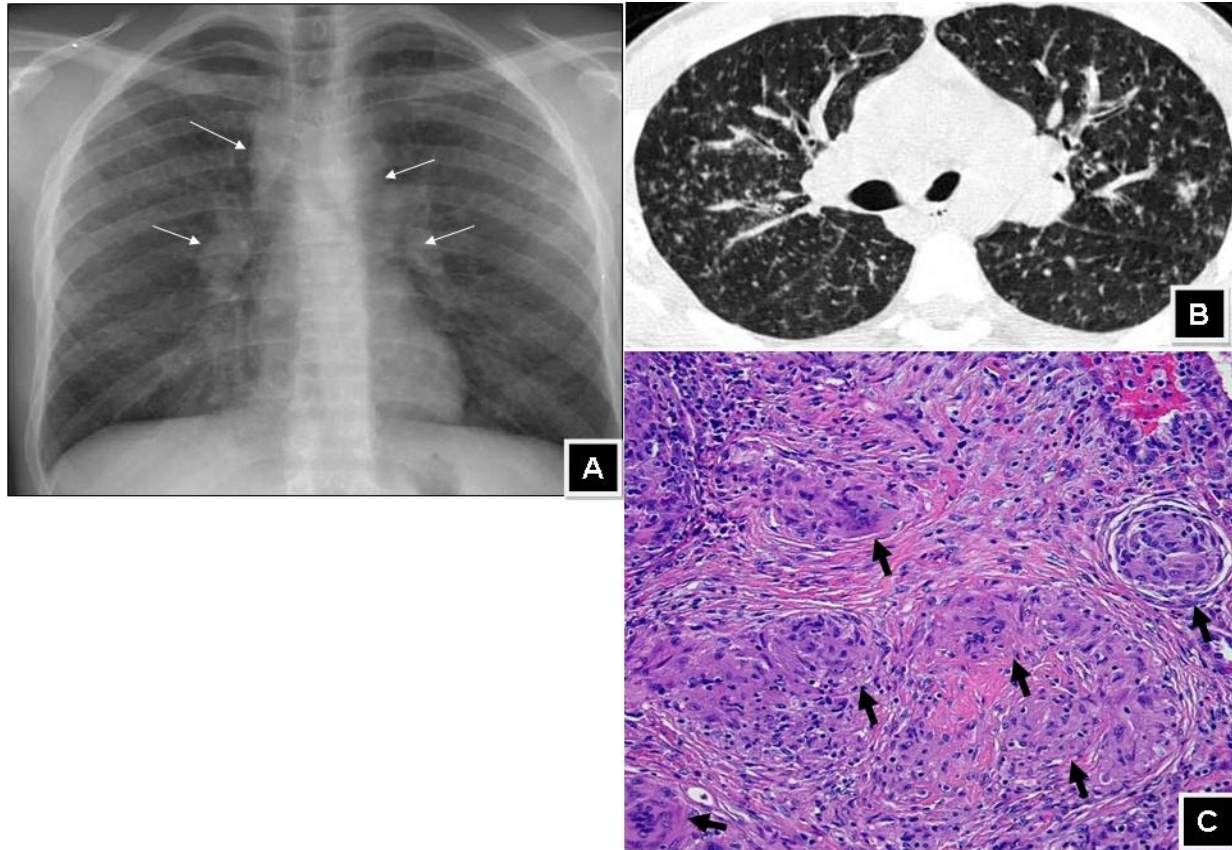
Stage 2 radiographic sarcoidosis with lymphadenopathy (arrows) on CXR (A), micronodular and macronodular infiltrates with beading along the fissure and bronchovascular bundles are more easily seen on CT (B), multiple lung granulomas of various sizes and stages of maturity on transbronchial biopsy (C).
